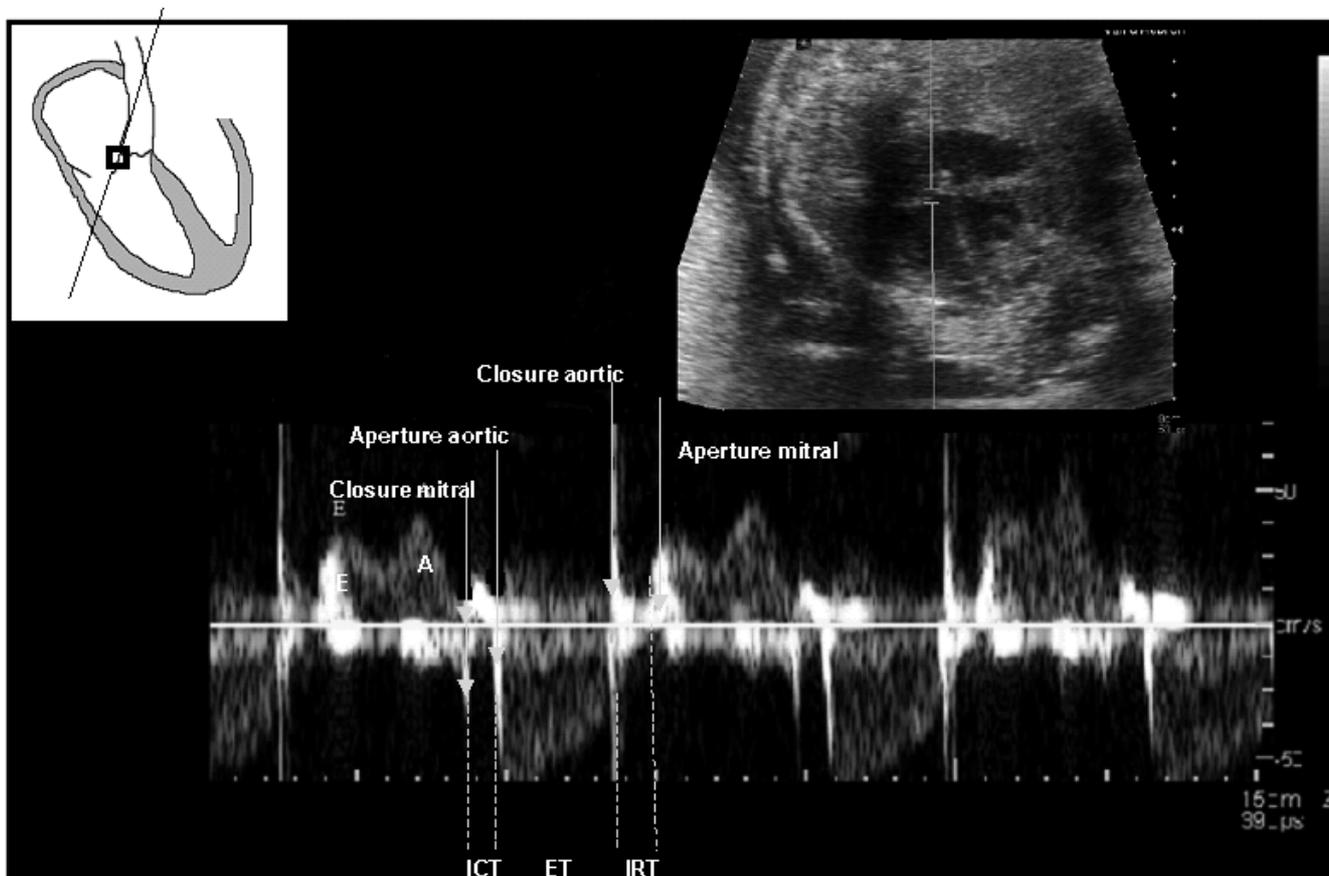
Doppler envelope of the modified myocardial performance index (Mod-MPI). The sample volume is located over the lateral wall of the aorta, close to the mitral valve. References for the time-period estimations are based on the echoes from the mitral and aortic valve movements. The E/A waveform is always displayed as positive flow. ET, ejection time; ICT, isovolumetric contraction time; IRT, isovolumetric relaxation time.
